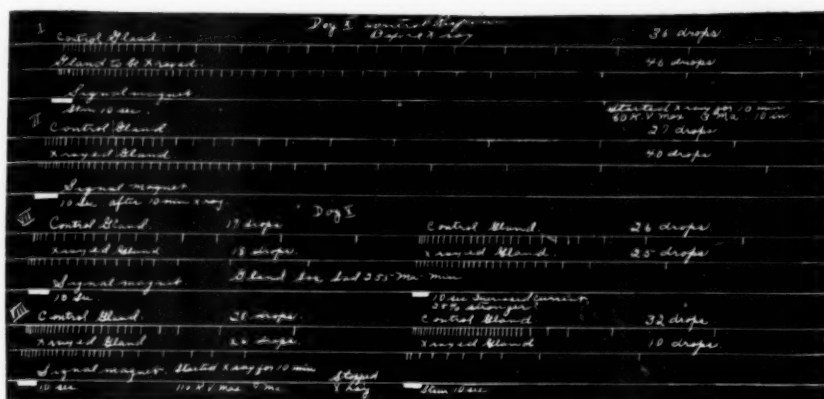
A portion of the tracings from which the results in Table II were derived. Tracings show the effect of large doses of x-ray on the secretory activity of the submaxillary gland under acute experimentation.
